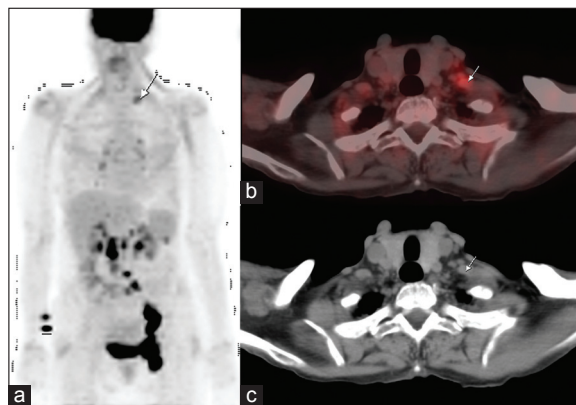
Maximum intensity projection image of a patient with diffuse large B cell lymphoma showing intensely F-18 fluoro-deoxy-glucose (FDG) avid disease below the diaphragm. F-18 FDG positron emission tomography/computed tomography (PET/CT) in addition identified metabolically active disease in subcentimetric left supraclavicular lymph nodes (which could have been missed by CT criteria of 1 cm for involved lymph nodes) and upstages the disease to stage III from stage II. This image highlights the incremental value of F-18 FDG PET/CT in staging patients with lymphoma over CT alone. PET/CT has been shown to be very useful in staging of lymphoma in comparison with anatomic imaging and frequently upstages the disease.^[5] Upstaging of disease can have therapeutic and prognostic implications as according to international prognostic index^[6] stage III/IV disease is associated with poor prognosis when compared to stage I and II disease
